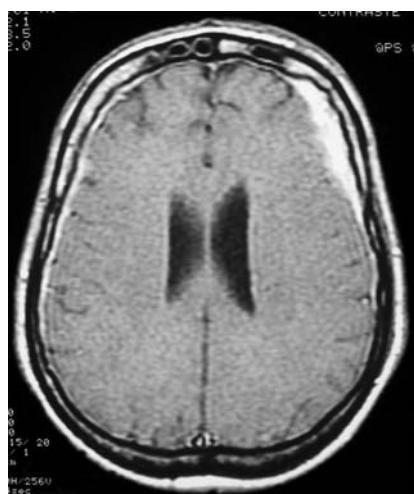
T1-weighted magnetic resonance imaging showing bilateral frontal subdural hematomas
